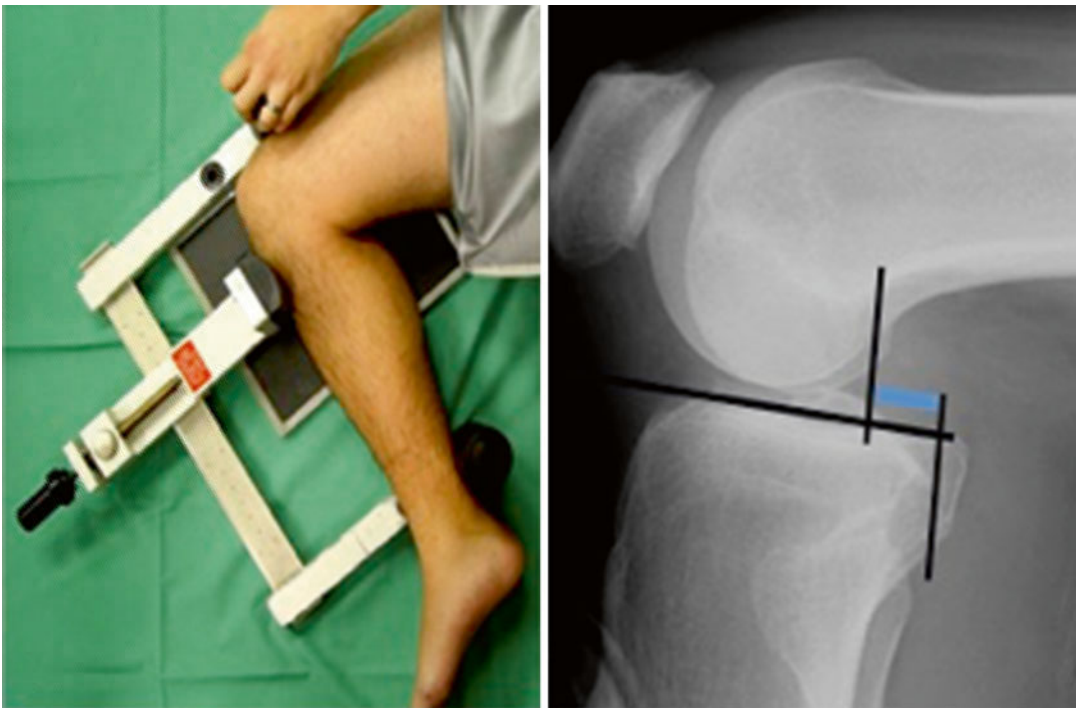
Telos stress x-ray for quantification of posterior translation
